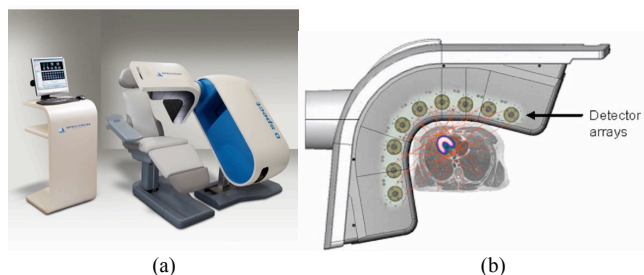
(a) Dedicated cardiac SPECT camera. (b) Sketch of the camera. (images from Ref. [78] © Institute of Physics and Engineering in Medicine. Reproduced by permission of IOP Publishing. All rights reserved).
